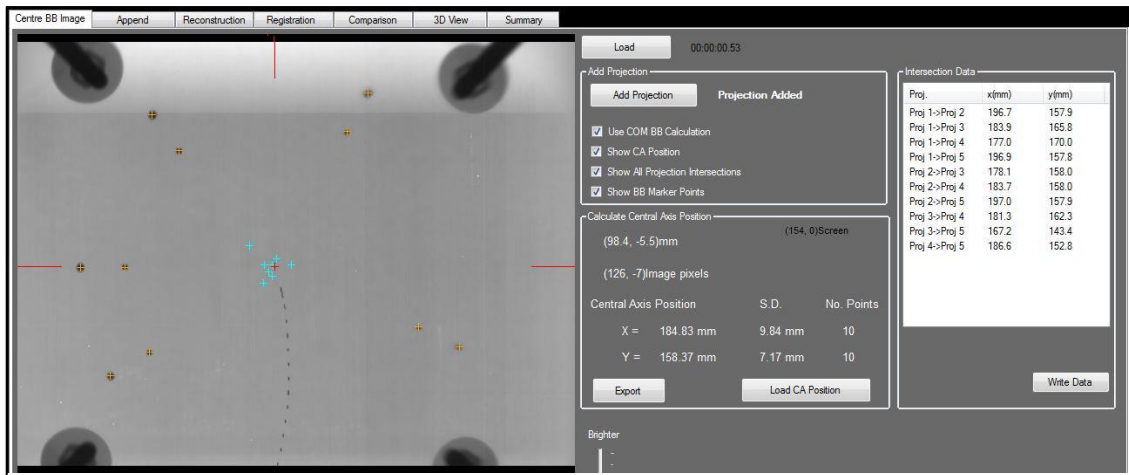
The in house software used to process the image to determine the x-ray central axis position. The centre of the projected BBs were identified by using a pixel intensity based centre of mass algorithm, and results are shown as yellow crosses. The intersection point of the projected BB pair lines are shown as cyan crosses and the calculated x-ray central axis position is displayed as a red cross.
